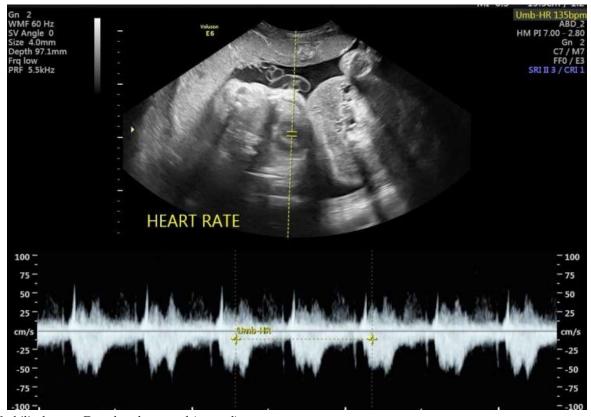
Umbilical artery Doppler ultrasound (normal)
